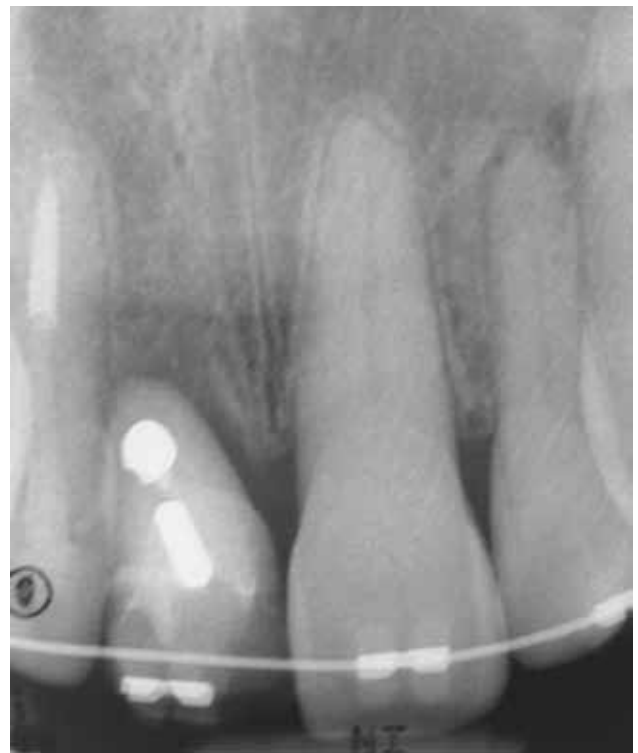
Radiograph after five weeks of orthodontic treatment.
